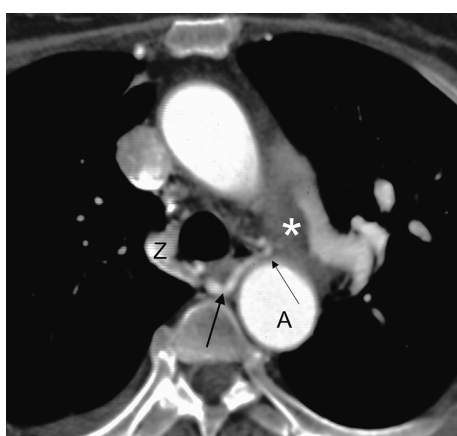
Multidetector computed tomography. Dilated bronchial arteries (arrows) are a common finding in chronic embolic pulmonary arterial hypertension. A = descending aorta; Z = azygos vein. * thrombus in the left pulmonary artery.
